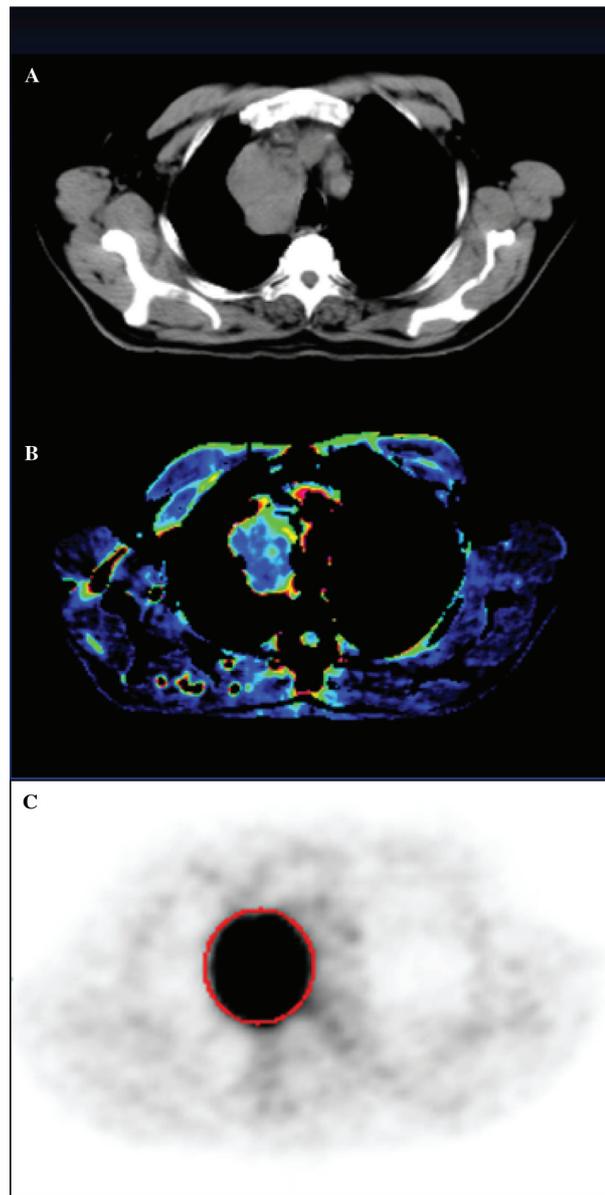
Conventional CT (A) and images of tumour blood flow (B) and glucose metabolism (C) acquired using perfusion CT and FDG-PET, respectively, from a patient with non-small cell lung cancer.
